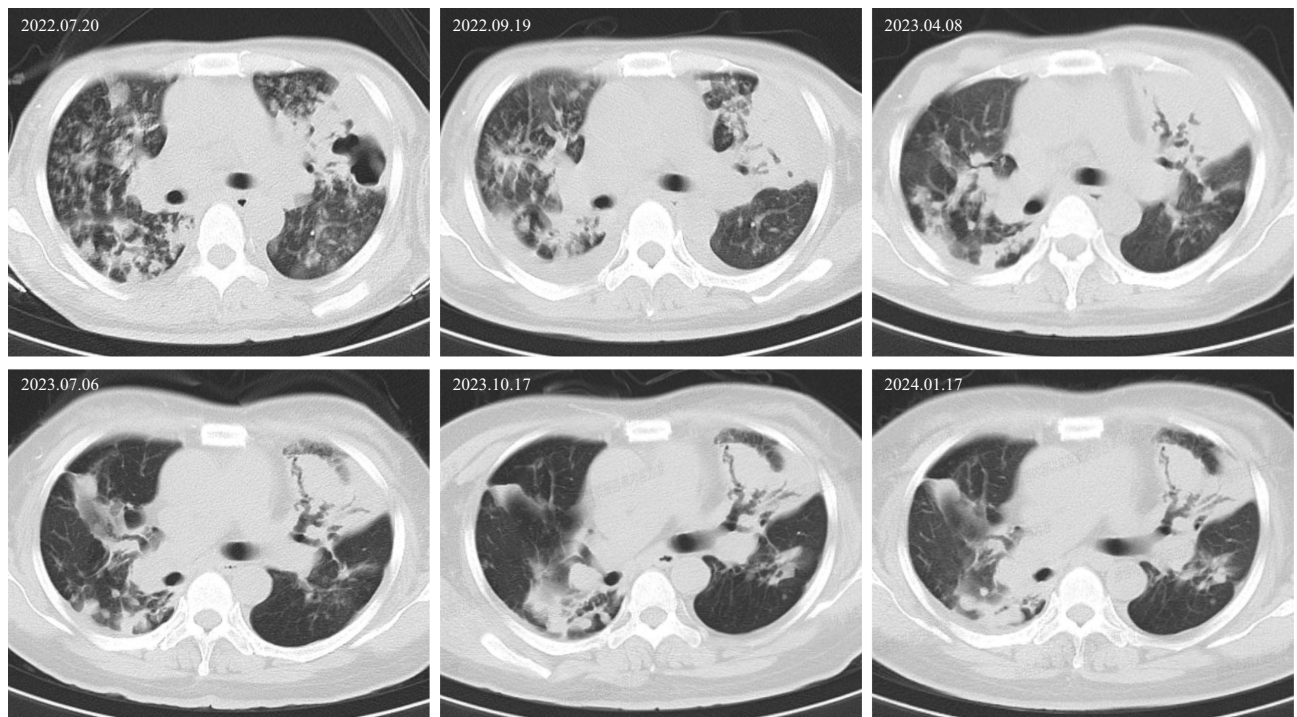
Case I: The dynamic changes in computed tomography scans of the patient following corresponding treatment. Starting from July 6, 2023, the lesions began to stabilize.
